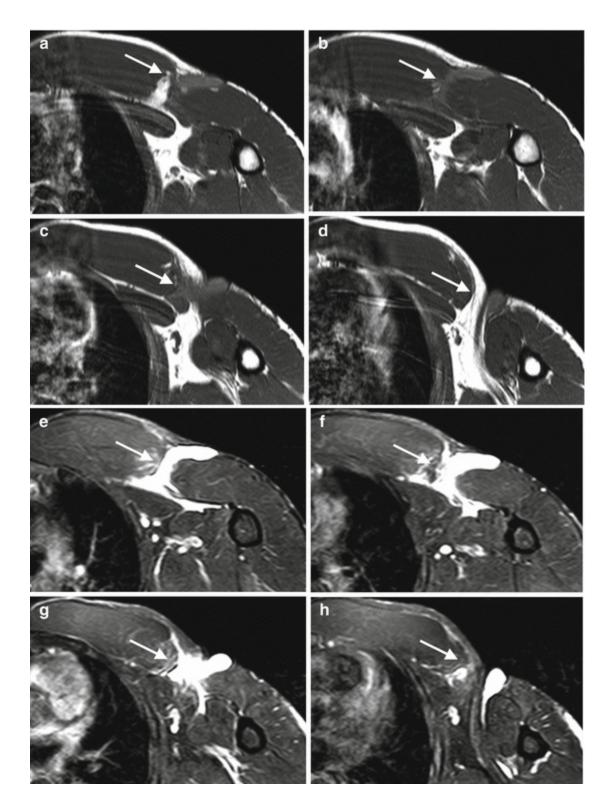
A 32-year-old man with a complete myotendinous junction tear after bench press exercise. Axial T1-weighted MRI show a complete distal pectoralis major tear (arrow, \mathbf{a} – \mathbf{d}) retracted proximally, superficial to biceps brachii short head. Axial fat-suppressed T2-weighted MRI demonstrate the fluid collection filling the tendinous gap and muscle fiber edema (arrow, \mathbf{e} – \mathbf{h})
